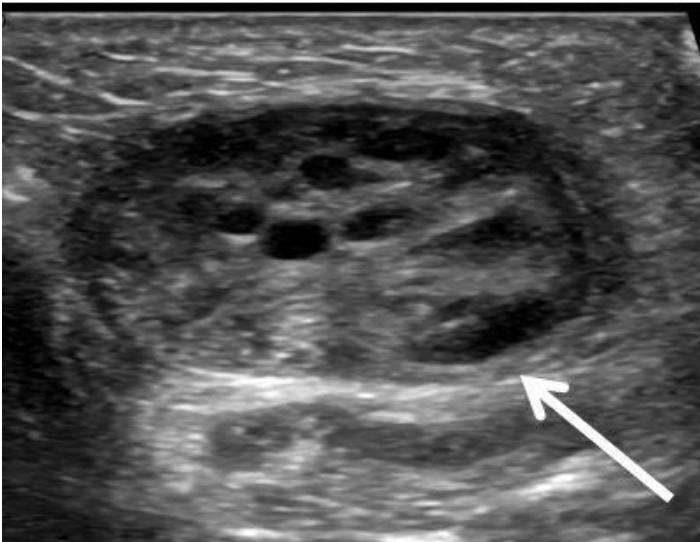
Ultrasonography (sagittal view) showing an incarcerated ovary (arrow) within an inguinal hernia.
